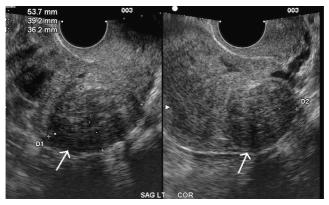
Ultrasound images of fibroids as shown.
